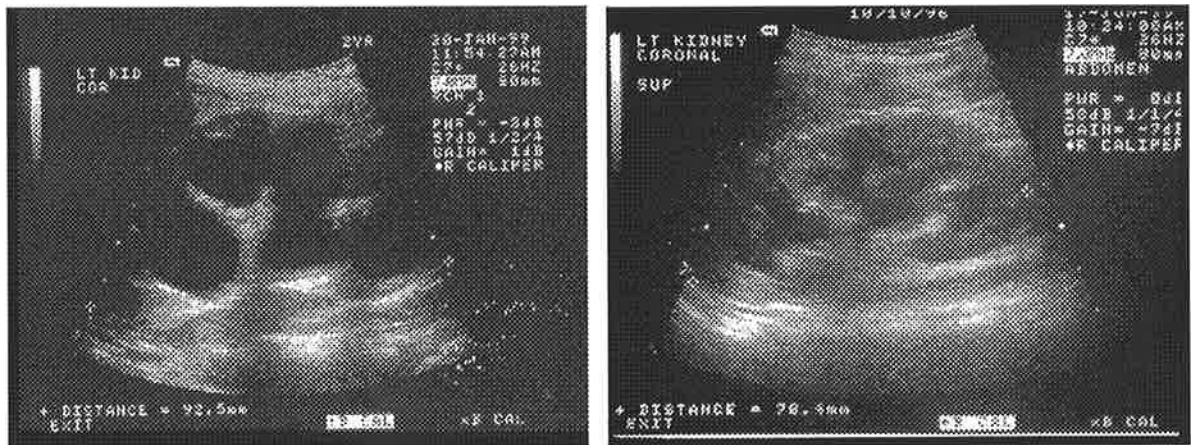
A preoperative ultrasound compared to the post-operative study, showing marked resolution of the hydronephrosis of *Case 4*.
